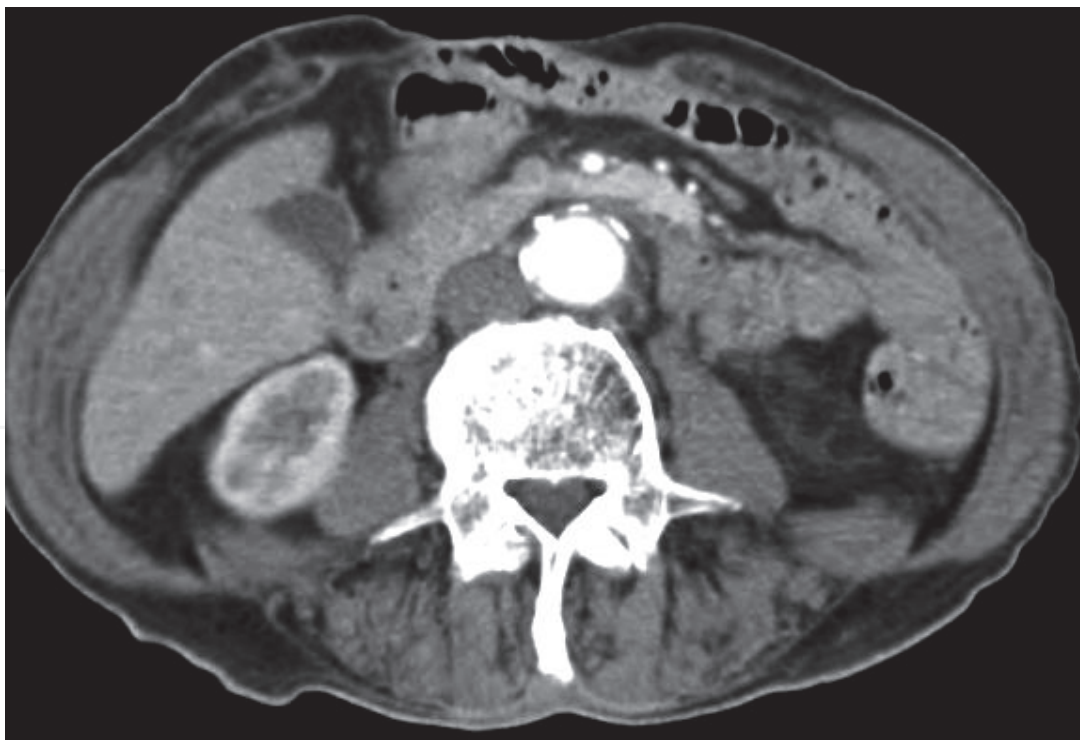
Abdominal CT angiography after percutaneous drainage of abscess and 2 years of antibiotic treatment.
